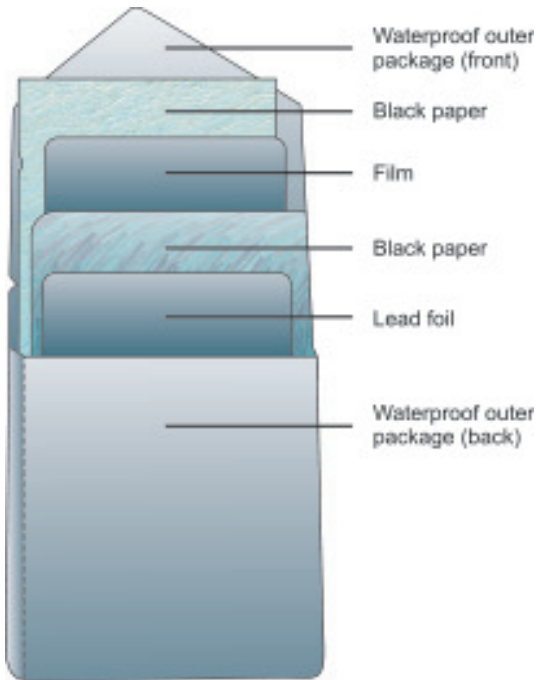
An X-ray film packet
